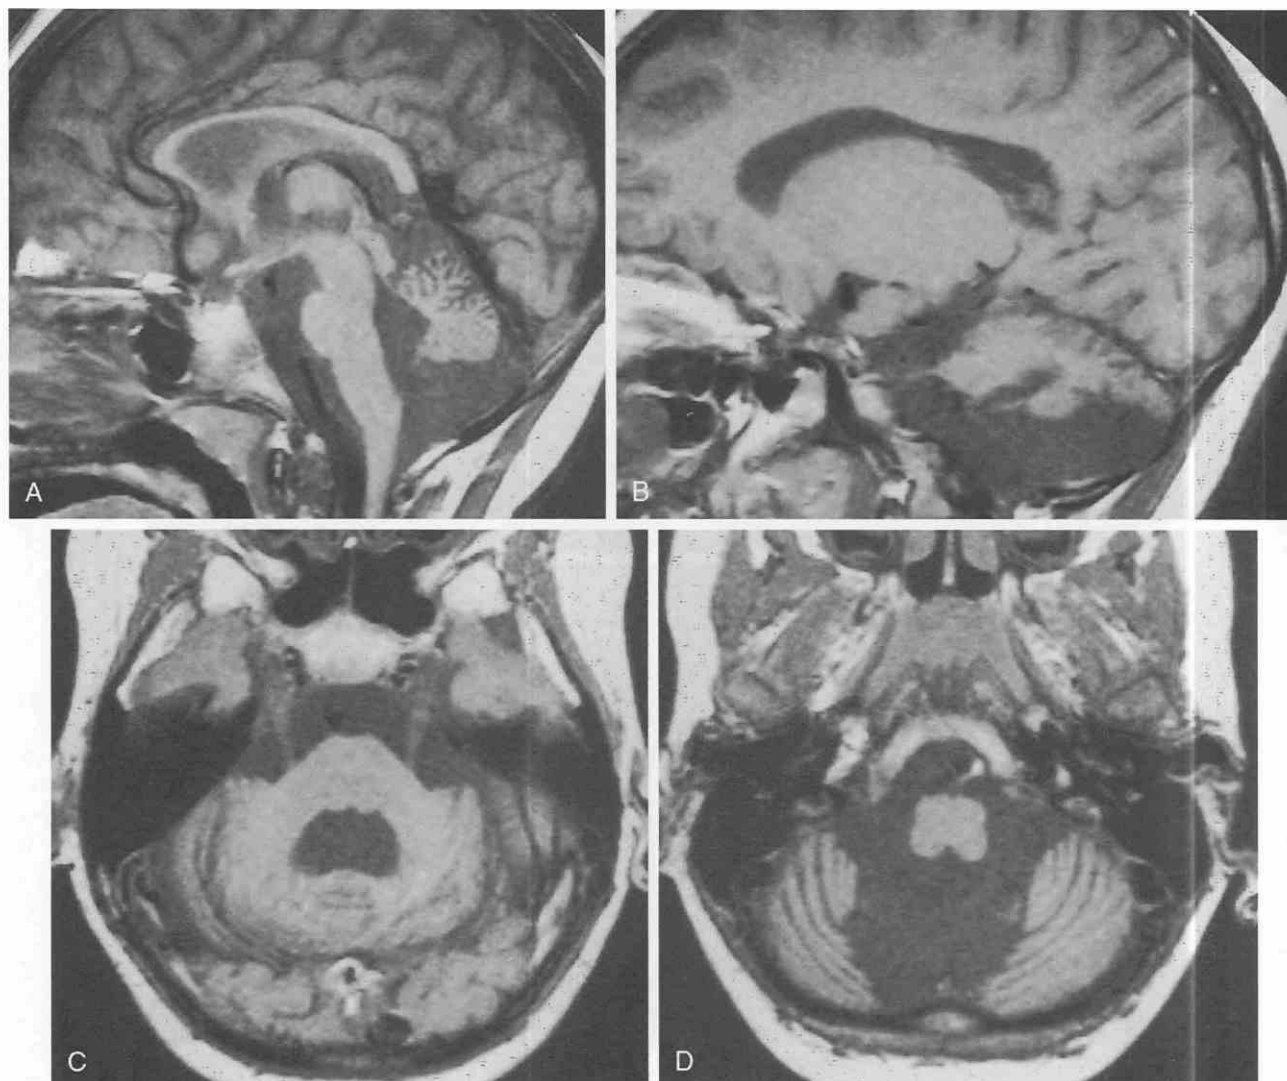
Progressive Friedreich's ataxia in a 4-year-old girl. Two sagittal (A and B) and two axial (C and D) T1-weighted images demonstrate severe atrophy of the cerebellum. (From Holodny AI, George AE, Golomb J: Neurodegenerative disorders. In Edelman R, Hesselink JR [eds]: Clinical Magnetic Resonance Imaging, 2nd ed. Philadelphia, WB Saunders, 1996.)
